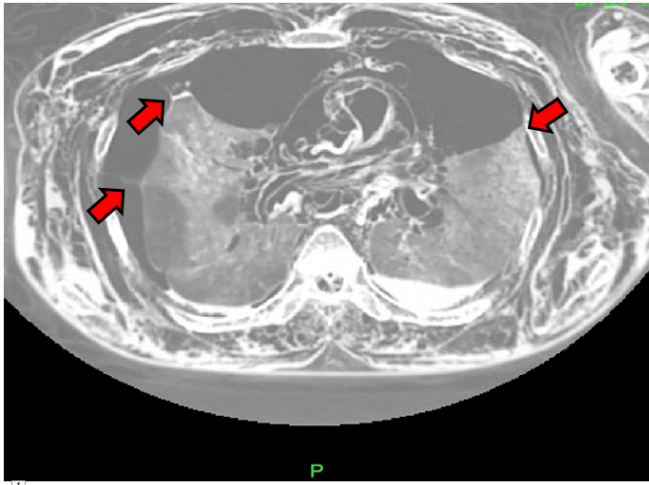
CT thorax showing the pulmonary fibrosis with adhesions
